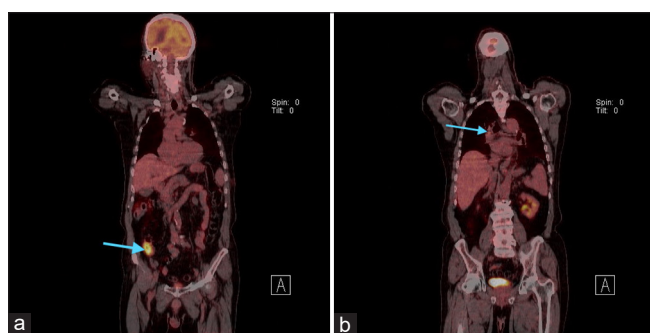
Positron emission tomography-computed tomography, coronal cuts, showing cecal thickening (a; blue arrow) with a standardized uptake volume of 14.6, and a mildly active right hilar lymph node (b; blue arrow) with a standardized uptake volume of 5.5.
